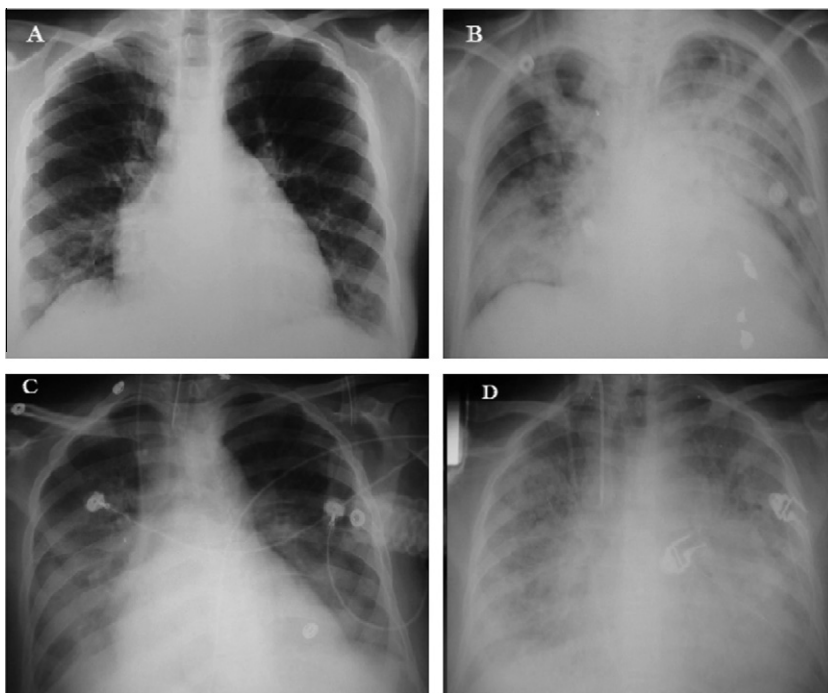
Chest X-rays of second episode of case no. 1. (A) Mild bilateral infiltrates at the onset 1st day of attack. (B) Bilateral ill defined diffuse opacities mostly involving the right lower and left upper zones at the 1st day of attack during frank hemoptysis. (C) Partial resolution of the infiltrates following 5th dose of pulse steroid therapy and pulse cyclophosphamide at 6th day of attack. (D) Bilateral ill defined diffuse opacities mostly involving the whole lungs at 10th day of attack before death of the patient.
